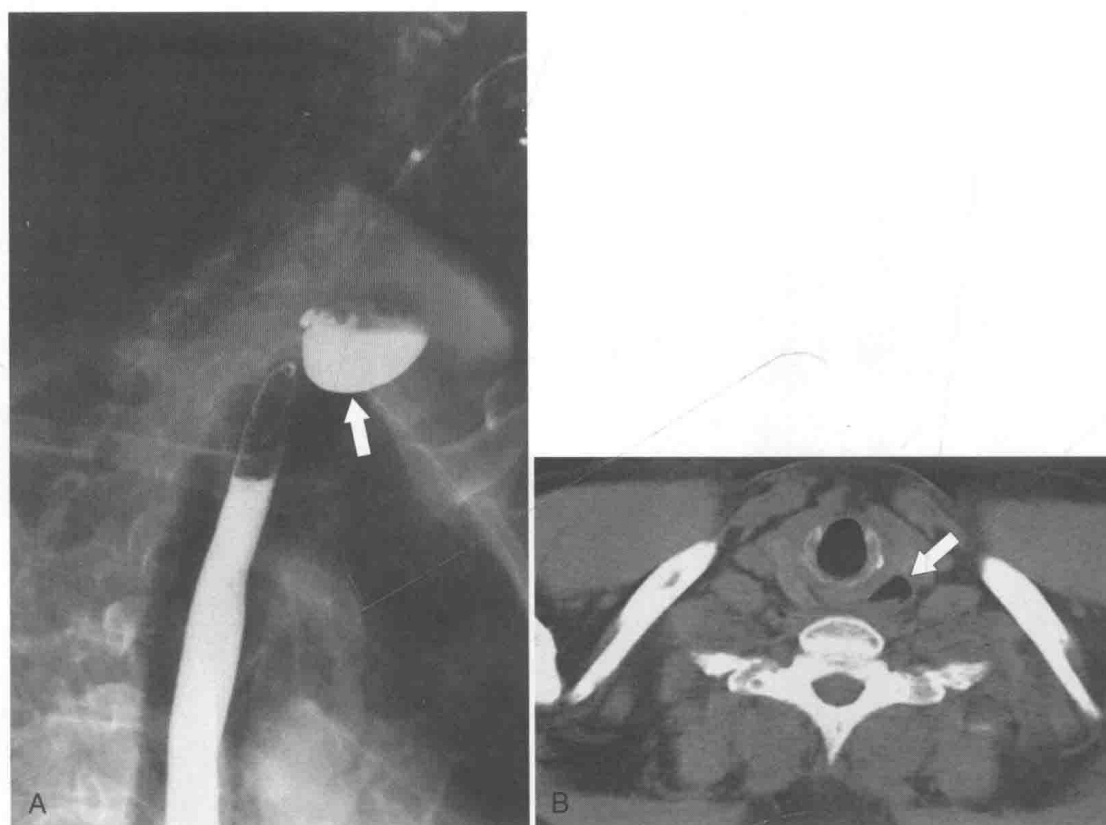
UGI swallow (A) and axial noncontrast (B) CT in a 71-year-old woman with a large Killian-Jamieson diverticulum (*arrows*).
